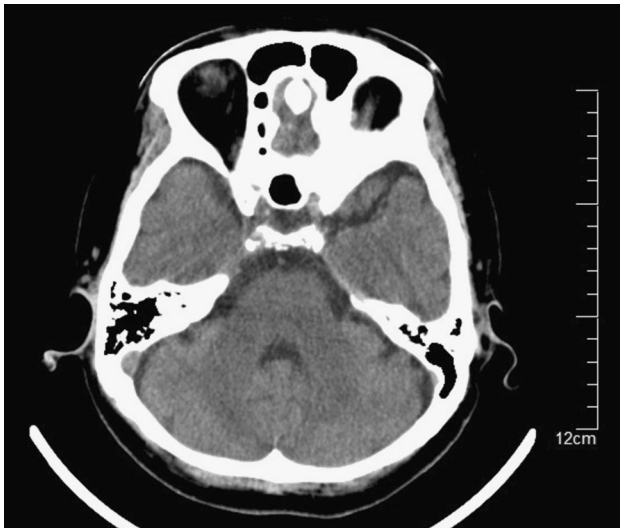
CT image on POD 13 shows no abnormality
